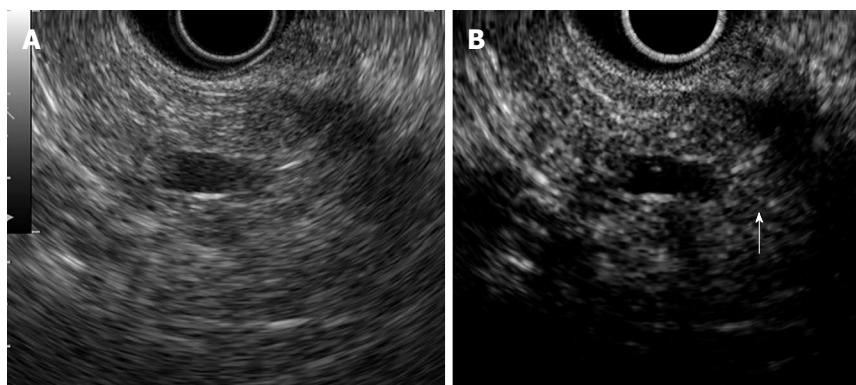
Contrast-enhanced harmonic-endoscopic ultrasonography images of pancreatic parenchymal perfusion. A: Conventional B-mode image; B: Contrast-enhanced harmonic image. Arrowhead indicates pancreatic parenchyma with small vasculature.
